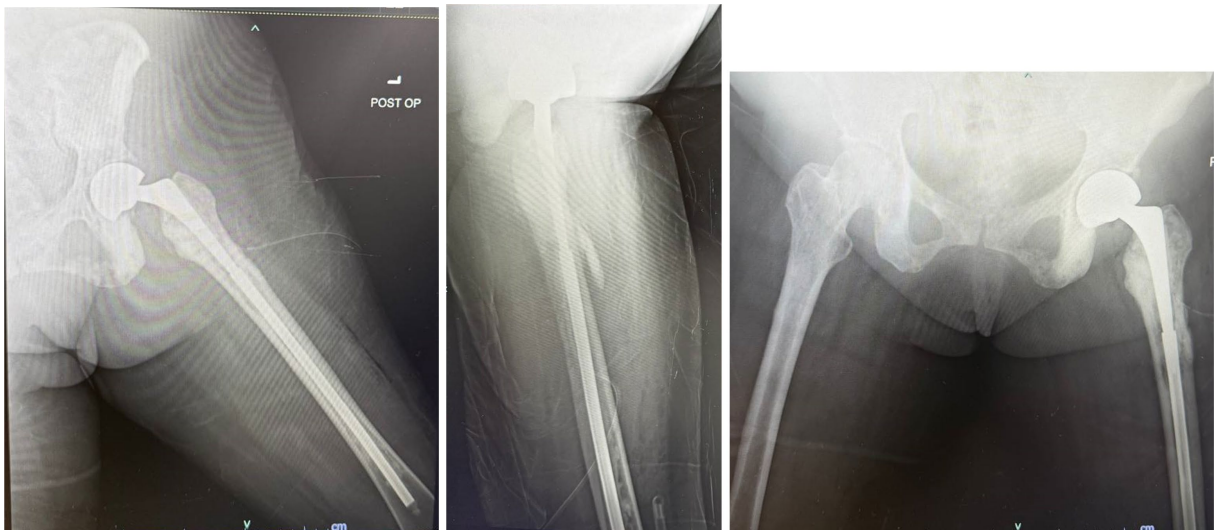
Post-operative X-rays showing good implant length obtained with the technique.
